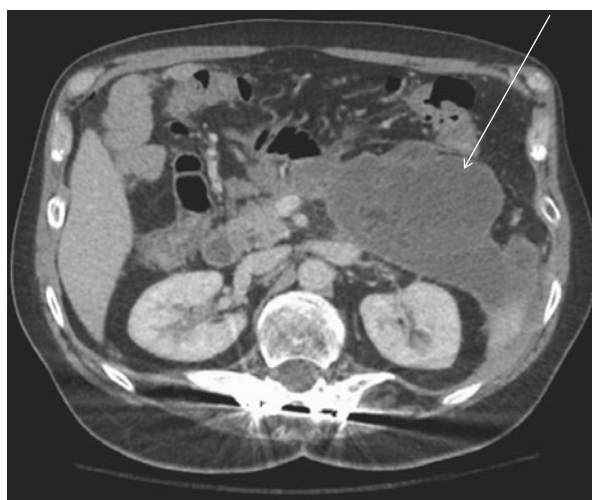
A CT image of an intra-abdominal abscess (*arrow*) amenable to percutaneous drainage
